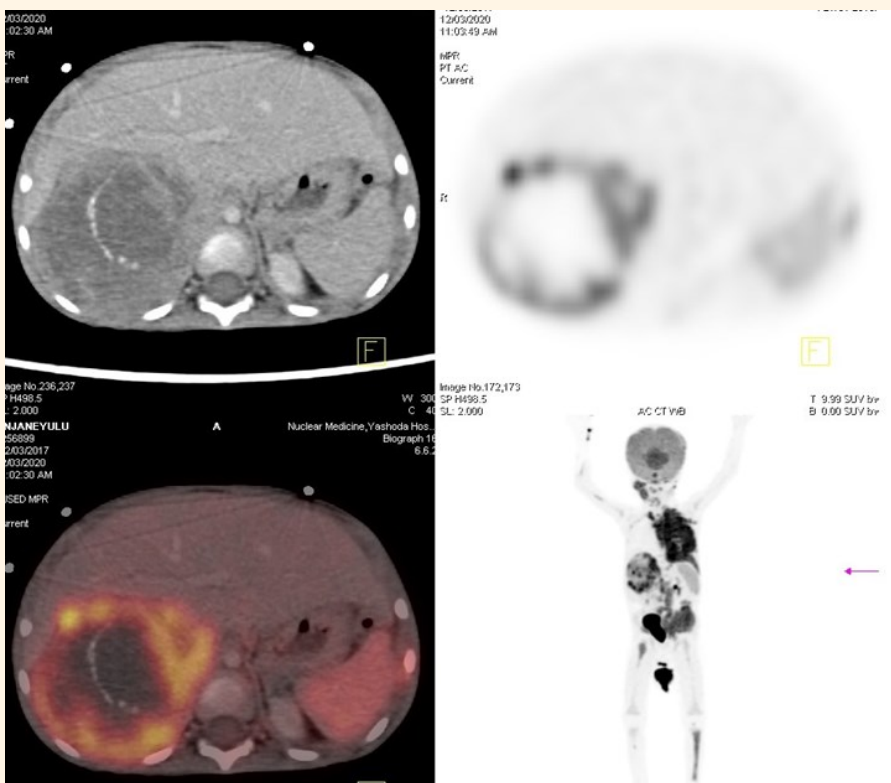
Whole body PET-CT Axial sections at the level of the adrenal showing Large irregular heterogeneously enhancing lesion involving the Right adrenal and abutting the adjacent surface of the Liver. The uptake on PET corresponds with the viable tissue and necrotic centre. The SUV Max measures 11.5
